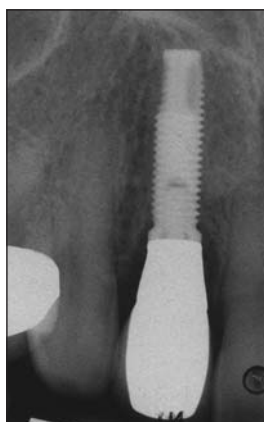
Two-year follow-up X-ray. Note stable interproximal bone.
